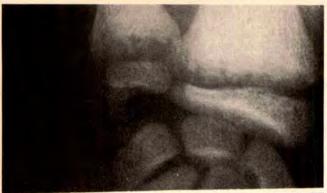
Roentgenograms of the wrist in a child with X-linked hypophosphatemia. Top, Rickets present at age 14 years, after 7 years of treatment with phosphate supplementation (up to 2000 to 4000 mg/d) and vitamin  $D_2$  (40 000 to 60 000 U/d), including an 8-month period when 25-hydroxyvitamin  $D_3$  was administered. These therapeutic measures were insufficient to heal rickets. Middle, Marked healing of rickets 6 months after replacement of 25-hydroxyvitamin  $D_3$  treatment with 1,25-dihydroxyvitamin  $D_3$  treatment. Note substantial narrowing of the epiphyseal plate and reduction of flaring. Bottom, Complete healing after 12 months of treatment with 1,25-dihydroxyvitamin  $D_3$  plus continued phosphate supplementation (from Chan et al<sup>22</sup>).
